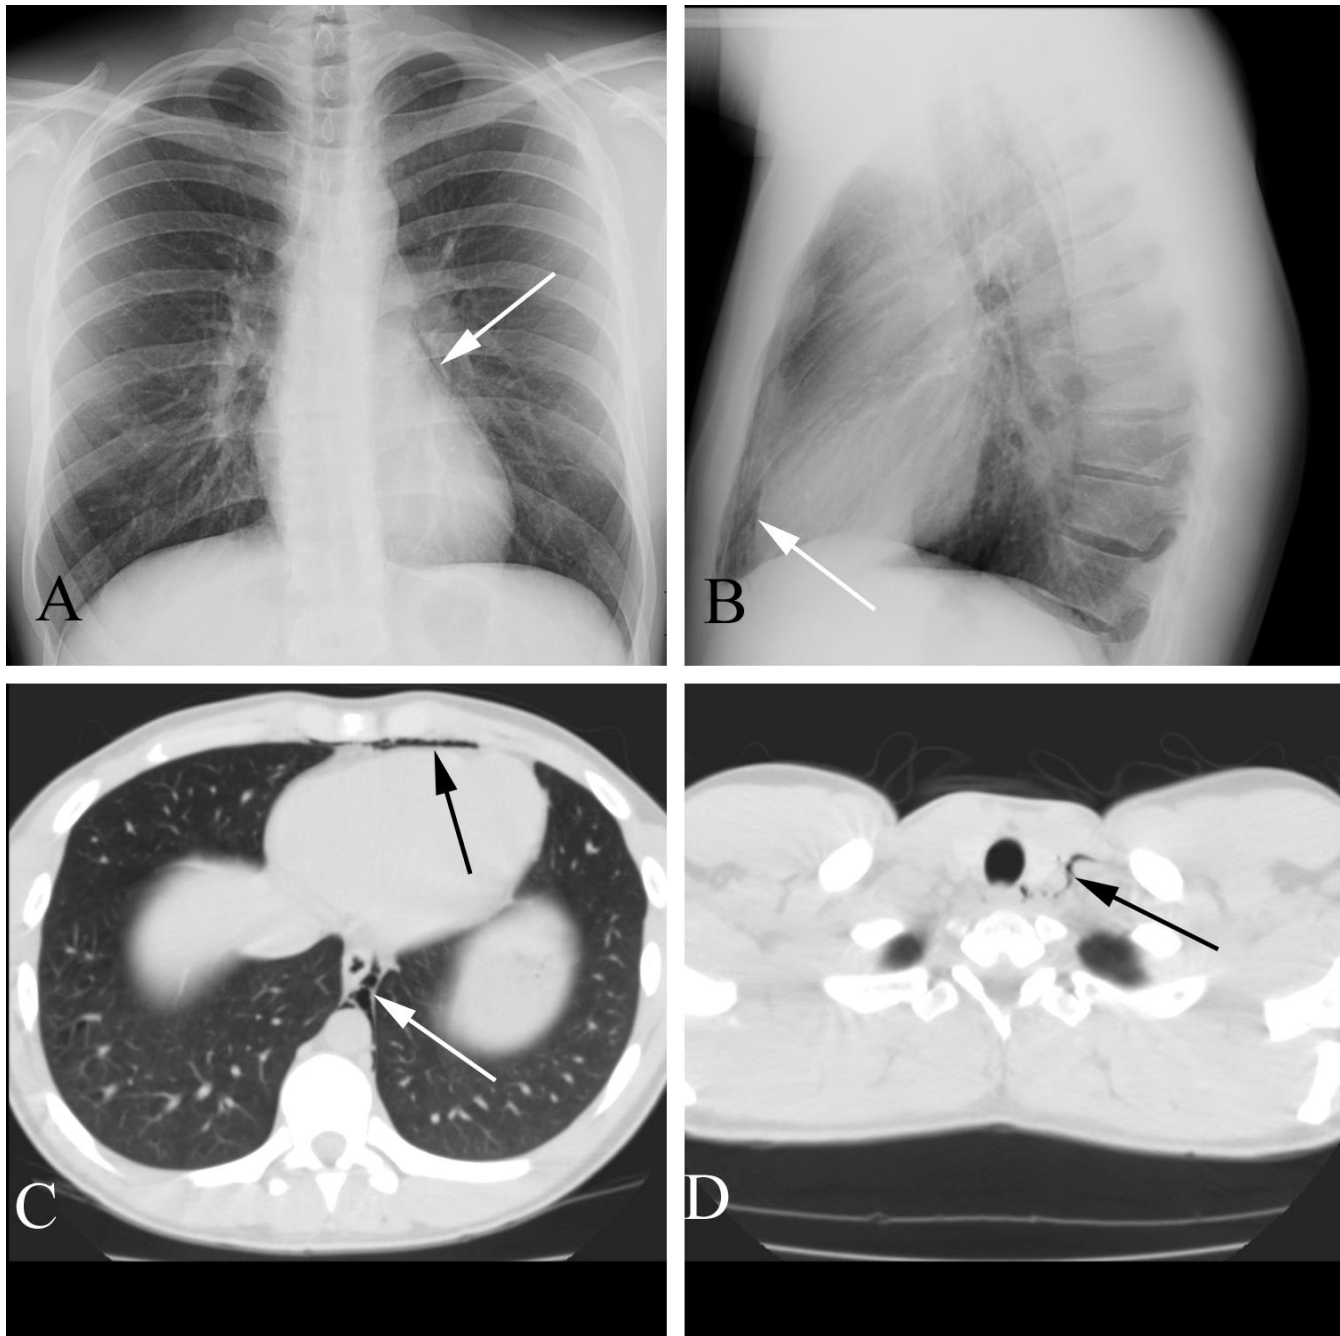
Pneumomediastinum causing chest pain in a 20 year old man. A. PA CXR shows only a subtle hyperlucency bordering the heart (arrow). B. Lateral CXR shows hyperlucency anterior to the heart (arrow). C. CT scan shows air anterior to the heart (black arrow) accounting for the lucency seen on the plain film, and air along the esophagus in the posterior mediastinum (white arrow). D. CT at the level of the thoracic inlet shows air dissecting along the left subclavian vessels (arrow).
